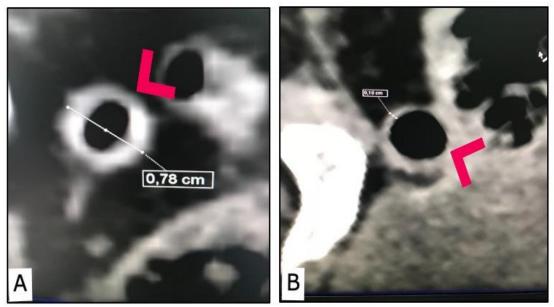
Measurement of diameter and the wall thickness of the appendix. A: amplification of a coronal CT where the white line represents the transverse diameter of the caecal appendix. (red arrow) B: amplification of coronal CT to measure the wall thickness of the caecal appendix (red arrow) represented by the white line.
